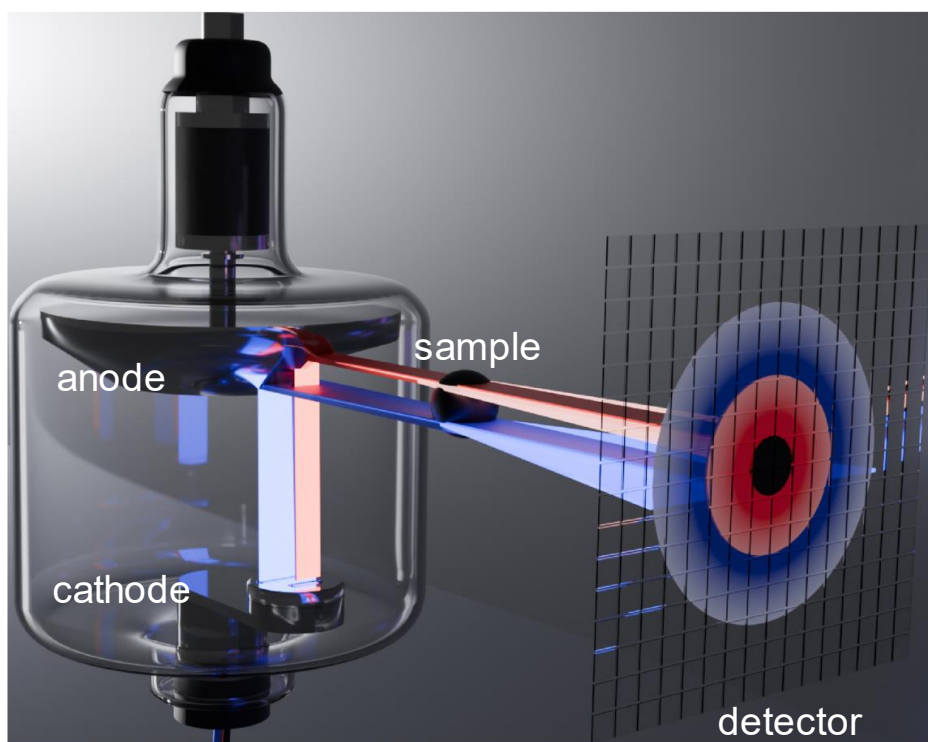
Scheme of an X-ray tube. Electrons are emitted from the cathode via thermionic emission and are subsequently accelerated towards the rotating anode by a voltage difference. The rapid deceleration of these electrons results in the emission of photons from a localized region on the anode, referred to as the focal spot. As will be discussed in the following subsections, key features of the X-ray tube, including the focal spot, play a critical role in determining image quality.
